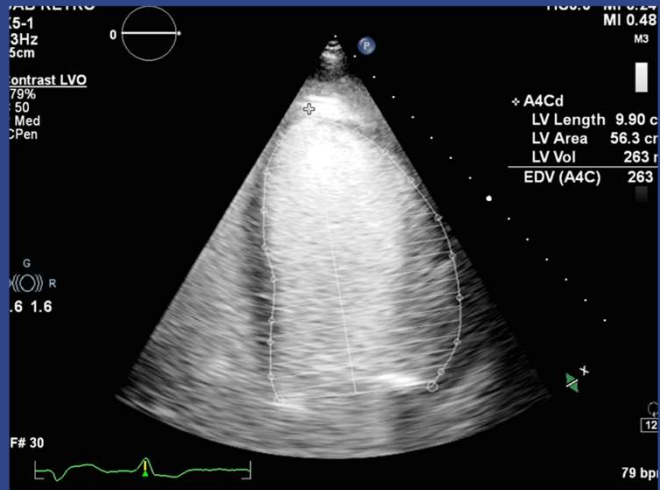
Apical 4 Simpsons by (M.Trump, 2025)
